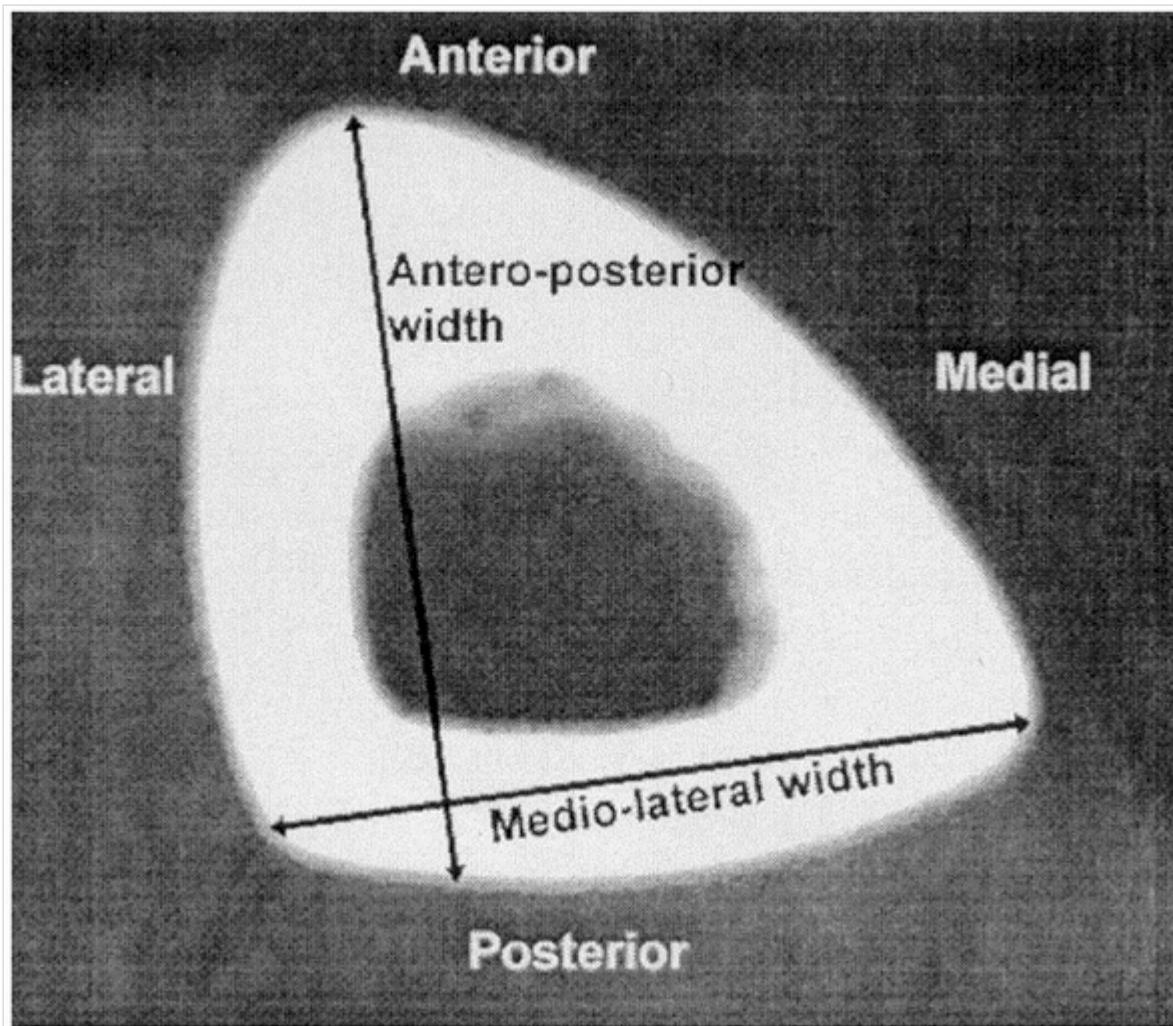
Tibial dimensions obtained via CT scans. Anteroposterior width; mediolateral tibial dimension.
